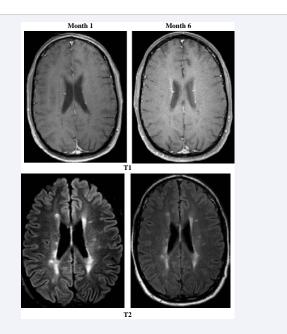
The MRI of brain of the reported patient. The brain MRI showed no enhancing or new T2 FLAIR lesions between drug holiday month 1 and month 6 after discontinuation of natalizumab. Axial T1 with contrast showed no new enhancing lesions. Axial T2 FLAIR showed no new lesions.
